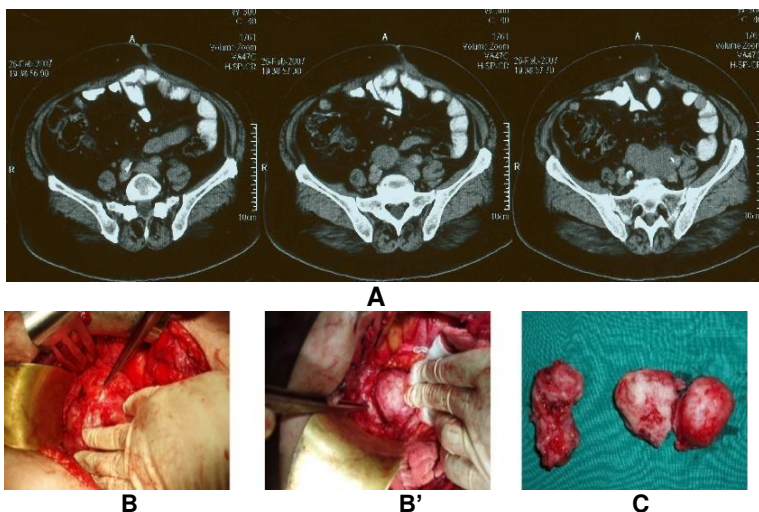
Leiomyosarcoma – CT aspect (A) și intraoperative (B, B') also the image of the excized piece of tumor (C)
